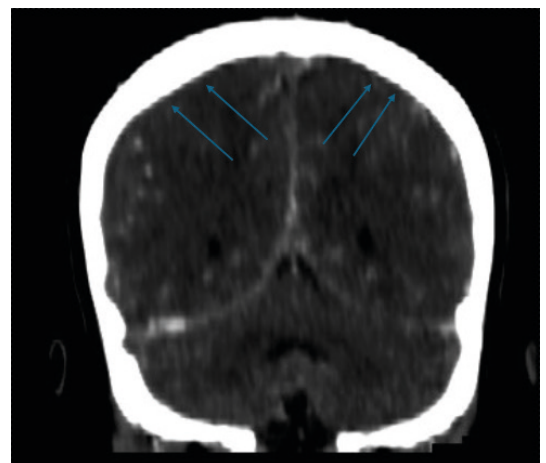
Contrast-enhanced computed tomography angiography of the skull showing: Filling failure in the superior anastomotic veins (Trolard).
